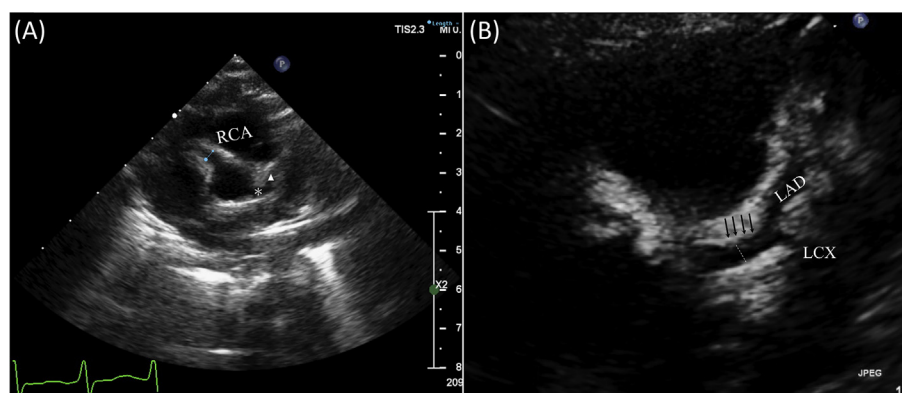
Precordial short-axis view (A) Echocardiographic image showing the LMCA (*), LAD (▲), and RCA. (B) Echocardiographic image showing the LMCA, LAD, and LCX. The LMCA diameter is measured at the middle of LMCA (dotted line).
